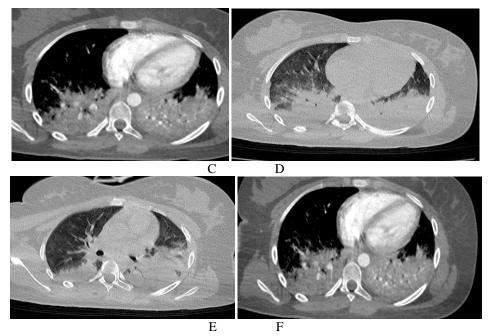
C, D, E and F: The results of chest CT angiography showing diffuse, ground glass opacities and consolidation in the lung
